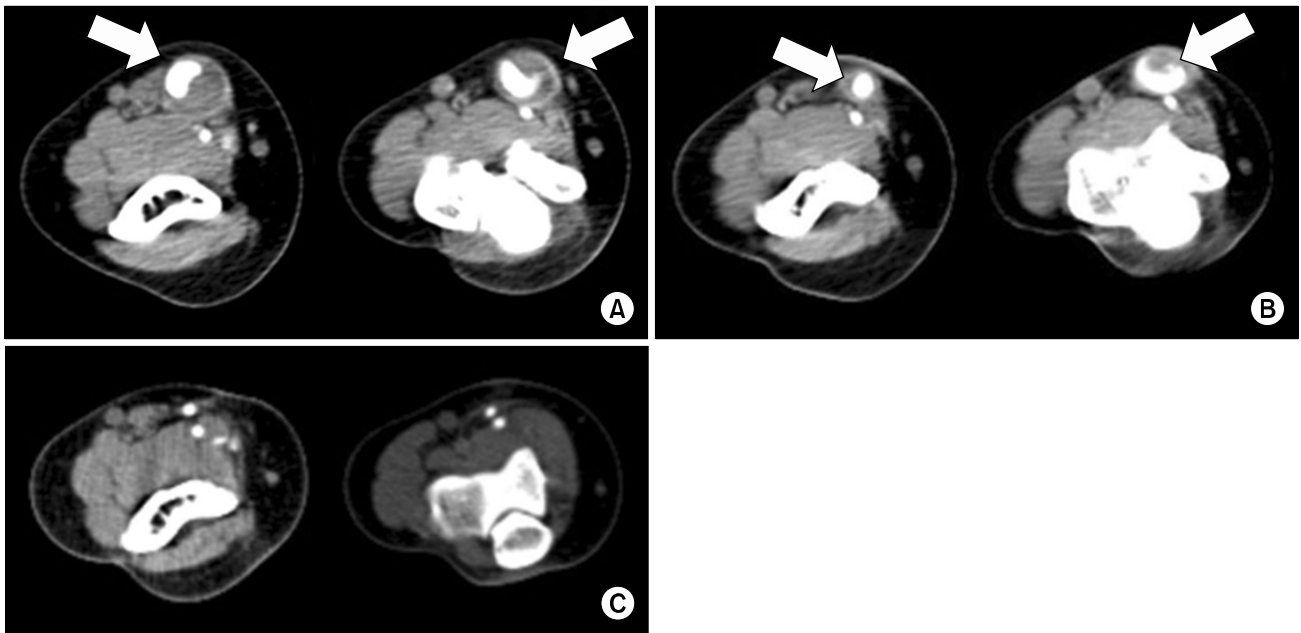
A comparison of the brachial artery at the same level. (A) Preoperative computed tomography of the first surgery showed aneurysmal changes with partial thrombotic aneurysm (Arrow). (B) Postoperative images of the first surgery (Arrow). The arrows show the recurrent aneurysm. (C) After the second surgery, the saphenous vein graft was intact without aneurysmal changes.
